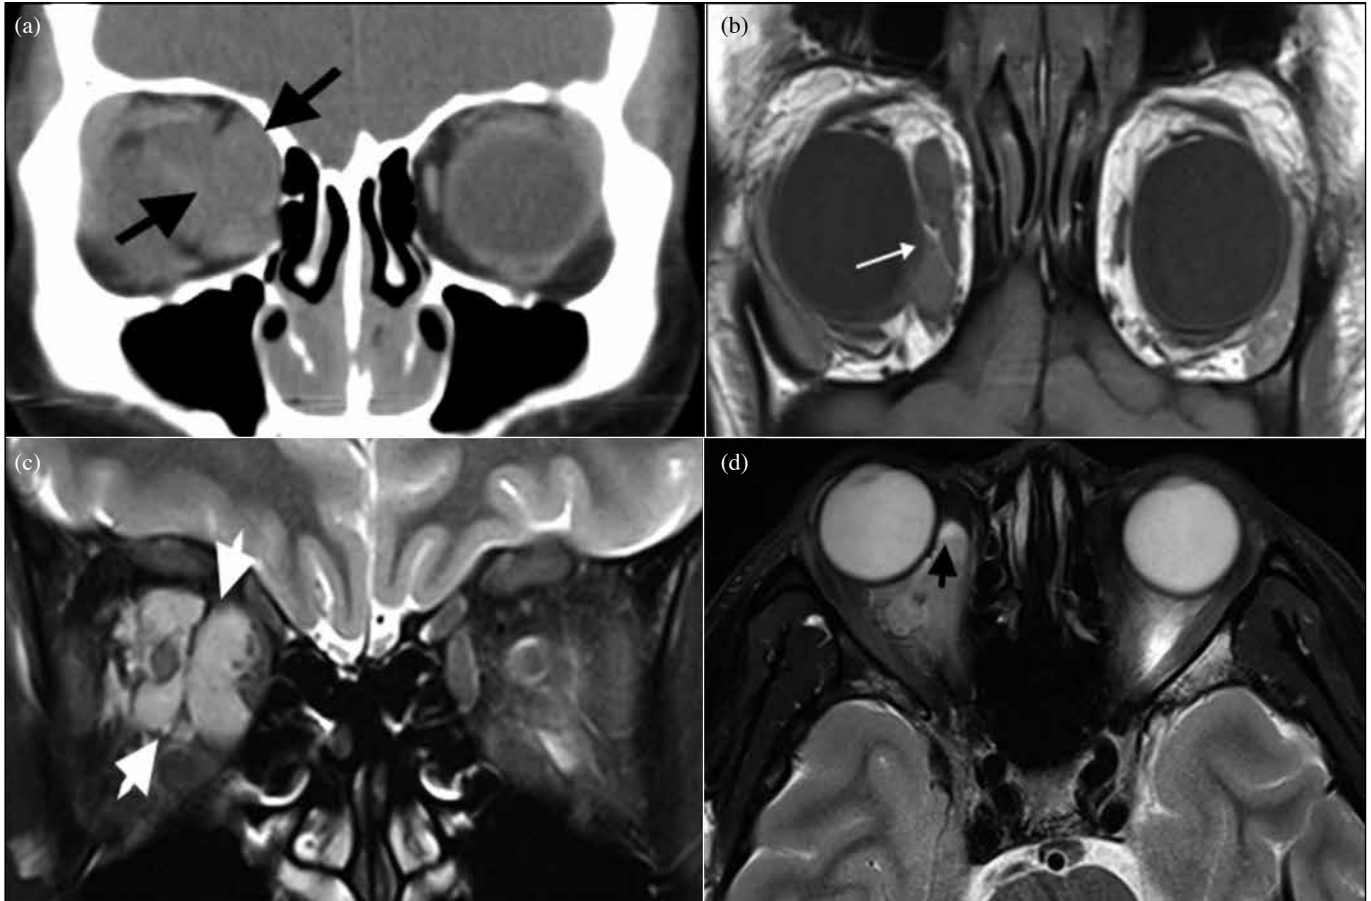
Patient 1: (a) Contrast computed tomography showing a soft tissue mass measuring 2.0×3.9×2.1 cm at the right retrobulbar intraconal region. (b) 3T coronal T1-weighted magnetic resonance imaging (MRI) at 4 weeks after onset of symptoms showing a multilobulated septated trans-spatial cystic lesion, slightly hyperintense to the extraocular muscle, occupying the right retrobulbar region. (c) Coronal T2-weighted MRI showing encasement of the optic nerve by the lesion and medial displacement of the medial rectus muscle. (d) Axial fat-suppressed T2-weighted MRI showing distinct fluid-fluid levels within the lesion suggestive of resolving intralesional hemorrhages.
